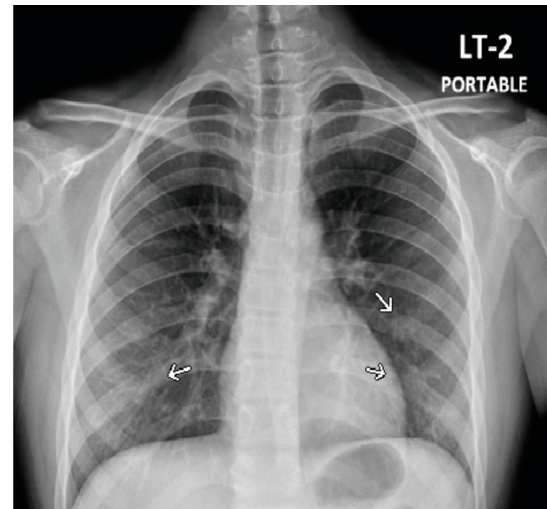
Chest X-ray shows faint ground-glass opacities both lower lungs of an 11-year-old boy with pneumonia in a cohort ward at Thammasat University Hospital, Thailand (day 2 after onset of illness).
